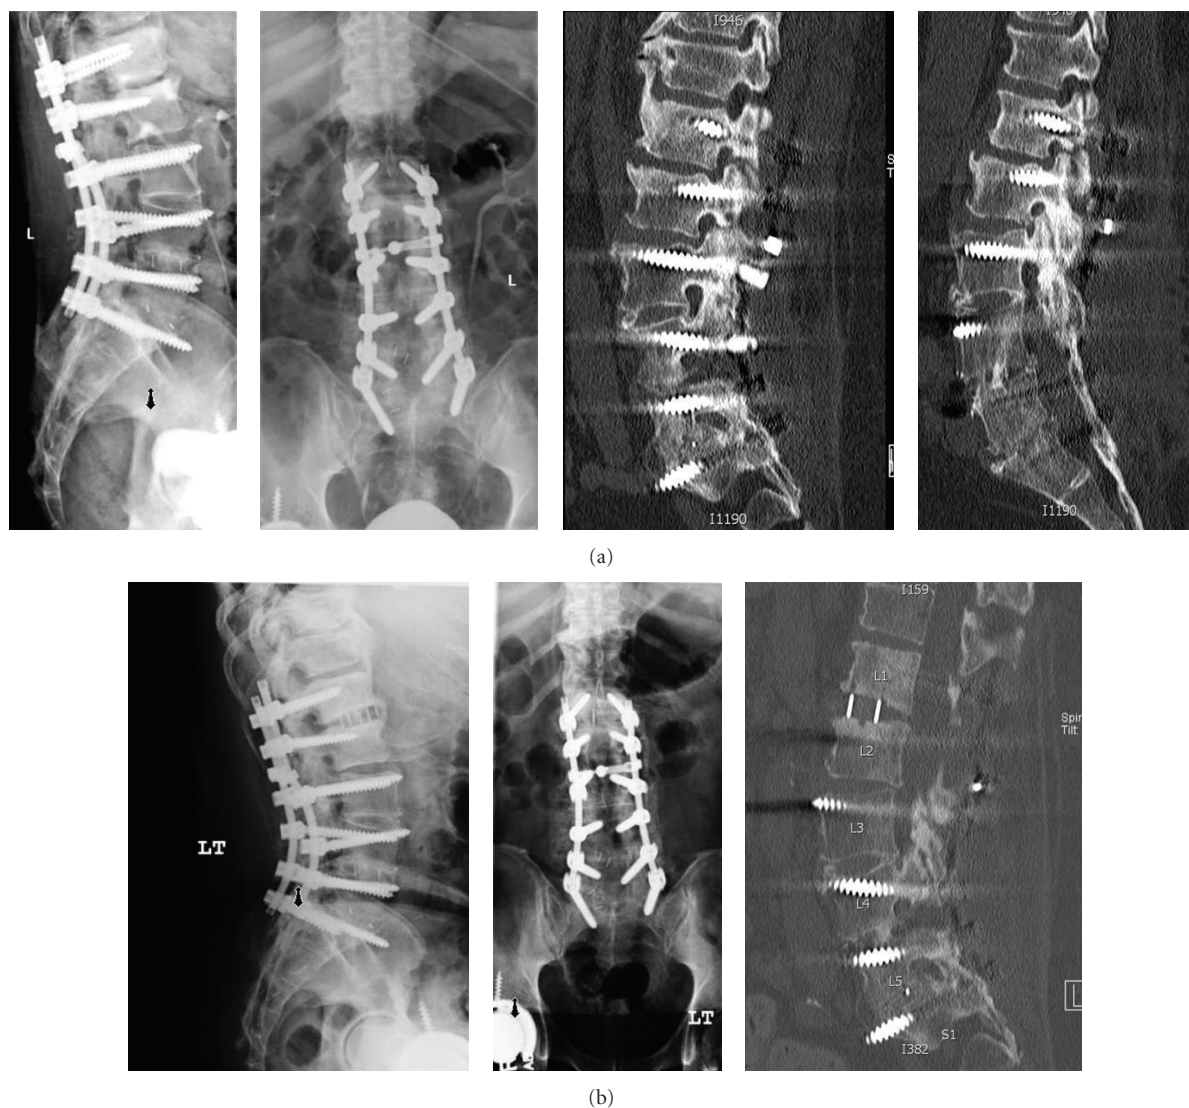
(a) Preoperative X-rays demonstrating nonunion at L1-2 after posterior instrumented fusion and decompression from L1-S1. (b) Postoperative X-rays demonstrating XLIF at L1-2.
